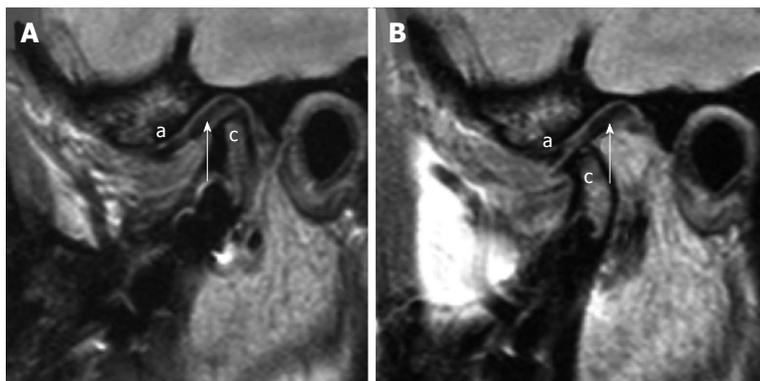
Stuck disk. A: Sagittal proton density weighted magnetic resonance imaging (MRI) in the closed mouth position demonstrates apparently normal position of the disk (arrow) in relation to the mandibular condyle (the letter, c). The letter “a” demonstrates the articular eminence; B: Sagittal proton density weighted MRI in the open mouth position demonstrates no anterior movement of the disk (arrow) with the mandibular condyle (the letter, c), *i.e.*, “stuck” to the glenoid fossa. The articular eminence is denoted with letter “a”.
